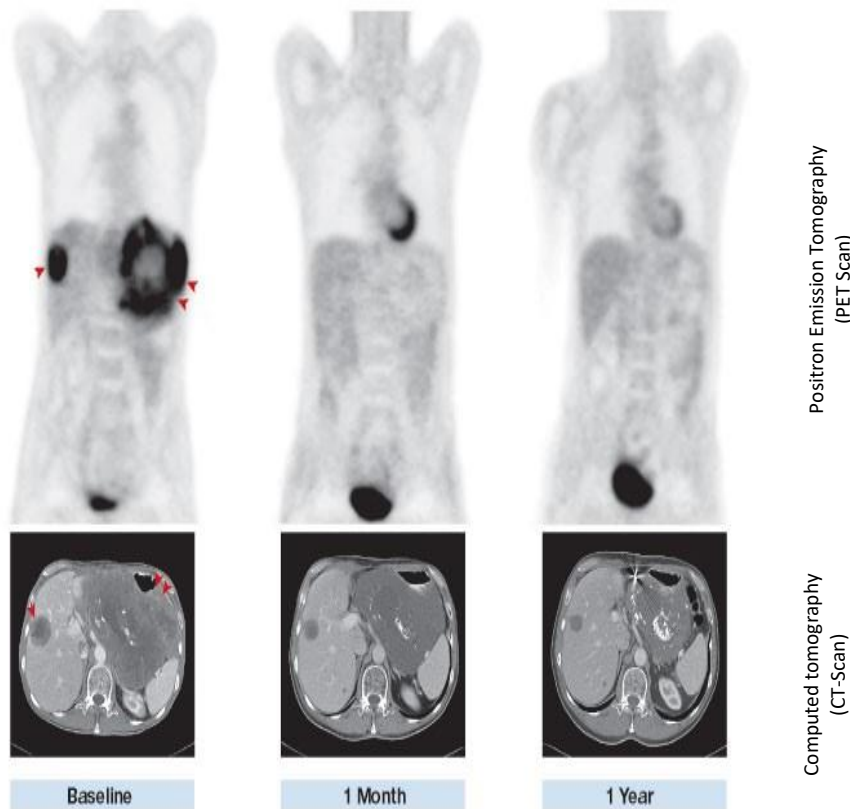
^{18}F FDG PET SCAN and CT-Scan of the Response of Gastrointestinal Tumors to Gleevec Treatment
